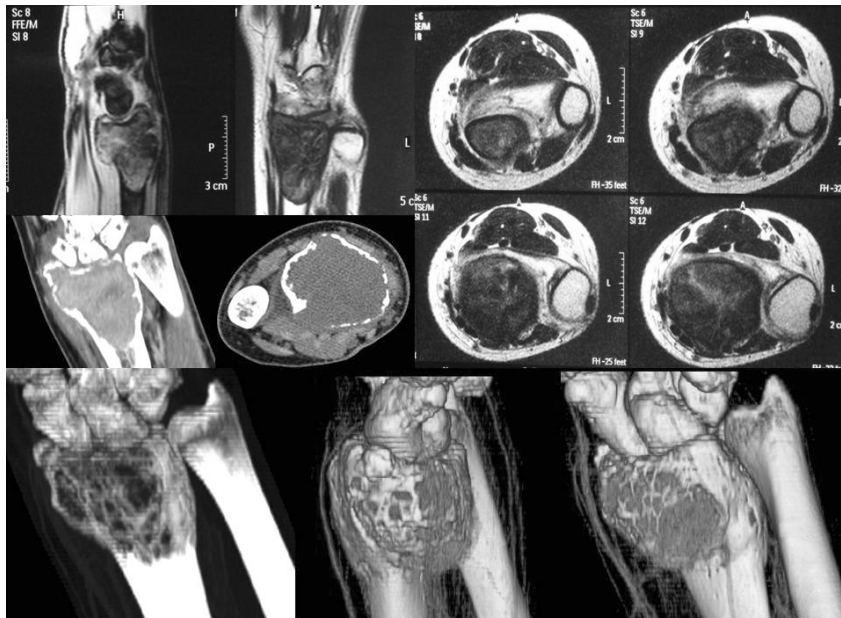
MRI and TC pictures of the giant cell tumor in the distal radius.
